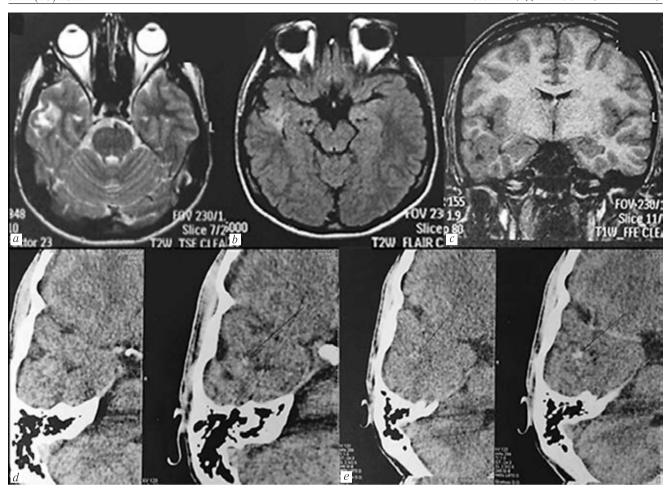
Пациент С. 15 лет. Результаты МРТ и КТ головного мозга. 1,5 Т МРТ показала участок патологического сигнала в правой височной доле в Т2, FLAIR (a, b) и Т1 (c). Участок демонстрирует трансмантийный признак, распространяющийся от височного рога гомолатерального бокового желудочка к корковой пластинке, без масс-эффекта и перифокального отека. Контрастное усиление не проводилось. На КТ выявлены очаги повышенной плотности до 59 единиц Хаунсфилда размерами 5.0×4.7 мм, 3.0×2.0 мм и 2.0×1.0 мм в базальных отделах правой височной доли, типичной для кальцинатов (d, e). Контрастное усиление также не проводилось
